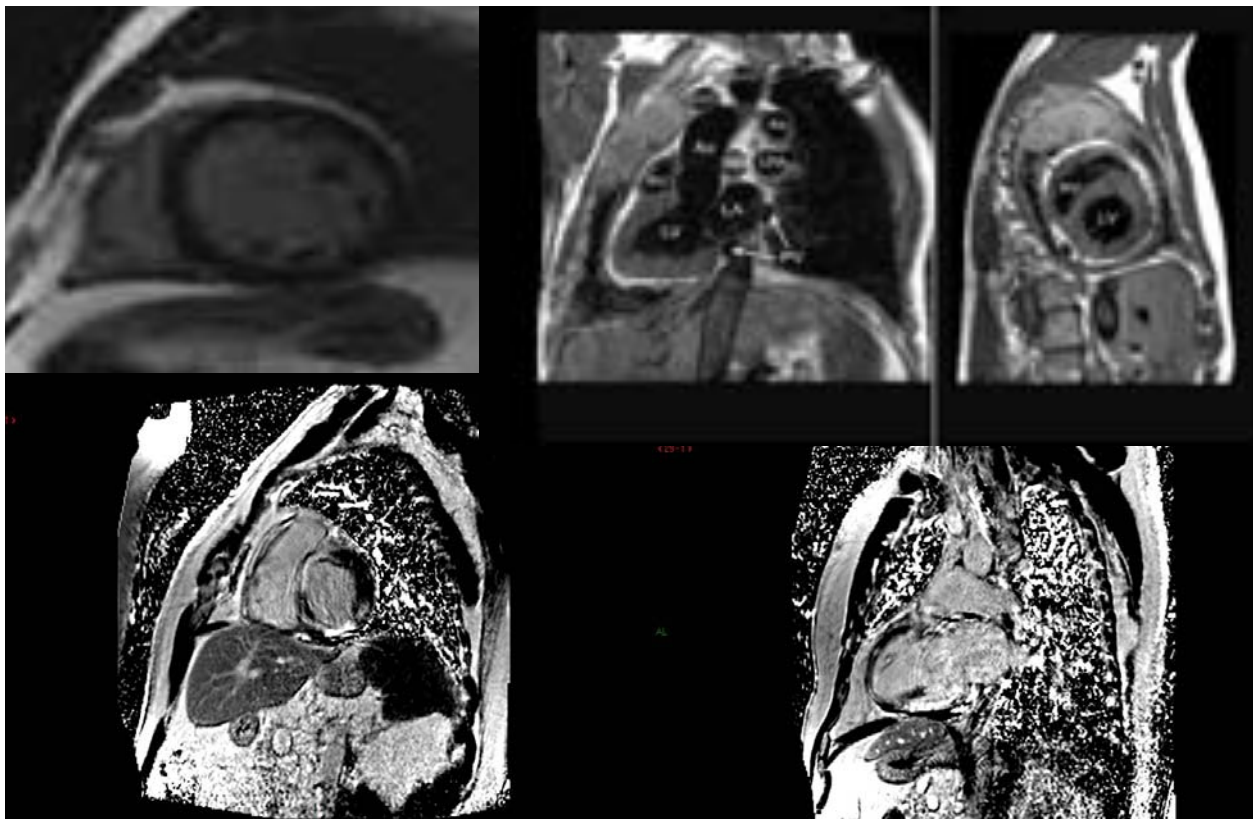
Cardiac magnetic resonance imaging (MRI) showing short-axis (left) and long-axis (right) views. Top, Normal MRI. Bottom, Patient MRI demonstrating areas of patchy midwall enhancement suggesting an infiltrative process.
